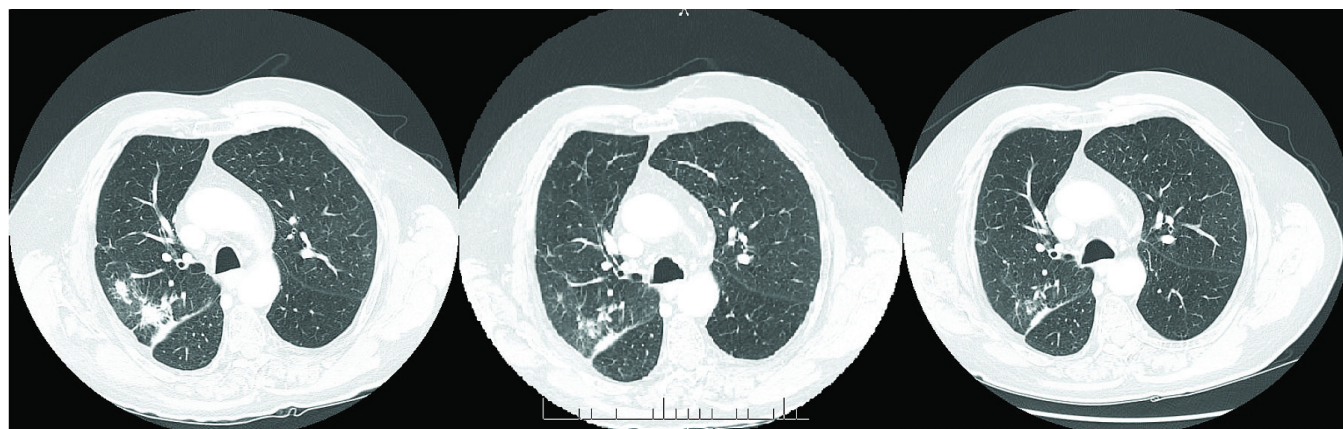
Axial computed tomography images showing lesion 3. Left to right: July 23, 2010: 2.0×1.7 cm; October 26, 2010: no longer measurable; February 11, 2011: further resolution.
